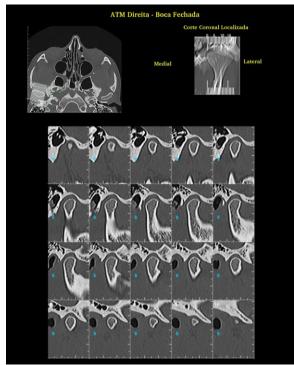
TC Cone Beam Mouth Closed - Right Side.
